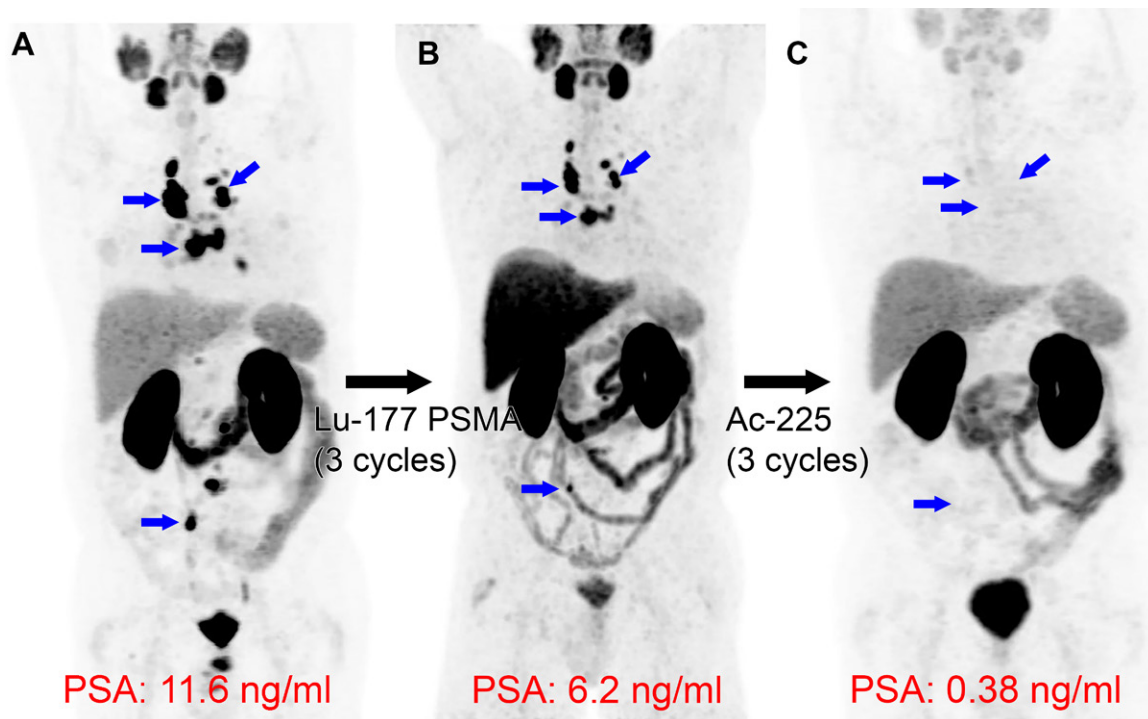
Actinium 225 (^{225}Ac) prostate-specific membrane antigen (PSMA) α -particle therapy following lutetium 177 (^{177}Lu) PSMA-617 β -particle therapy. Images in a 71-year-old man with widely metastatic prostate cancer, with a Gleason score of 7 (3 + 4), that progressed despite androgen deprivation therapy, taxane-based chemotherapy, and thoracic spine stereotactic radiation. (A) Baseline gallium 68 (^{68}Ga) PSMA-11 PET/CT image demonstrates intense PSMA uptake in many nodal metastases (blue arrows). (B) Following three cycles of the targeted β -particle therapy with ^{177}Lu -PSMA-617, the ^{68}Ga -PSMA-11 PET/CT image demonstrates persistent PSMA-avid disease (blue arrows), with a mild reduction in prostate-specific antigen (PSA). (C) Following three cycles of the targeted α -particle therapy with ^{225}Ac -PSMA-617, nearly complete resolution of uptake in the nodal metastases is observed (blue arrows in the location of previous nodal uptake), with a substantial reduction in PSA level.
